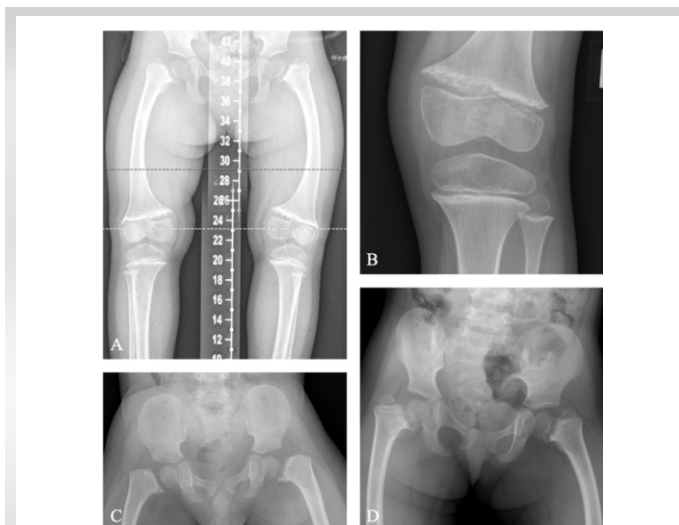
Radiographic features of metaphyseal chondrodysplasia, Schmid Type (A-D) A: Diffuse metaphyseal flaring, irregularity and physeal widening at the hips, knees and ankles. Coxa vara with bowing of the femora. B: Diffuse metaphyseal flaring, irregularity and physeal widening involving the distal femur, proximal tibia and fibula but most prominent at the distal femur C: Diffuse metaphyseal flaring, irregularity and physeal widening at the hips. Coxa vara. D: Diffuse metaphyseal flaring, irregularity and physeal widening at the hips. Coxa vara.
